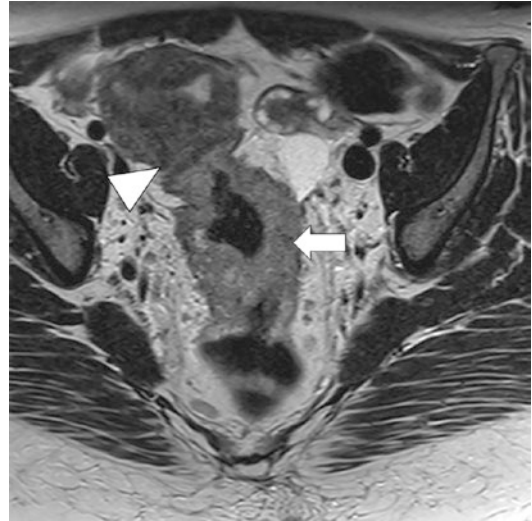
High-resolution, T2-weighted axial image through the pelvis for the purpose of rectal carcinoma staging. The higher resolution allows for precise delineation of disease extent, in this case a T4 rectal carcinoma (arrow) with involvement of the adjacent uterus (arrowhead)
